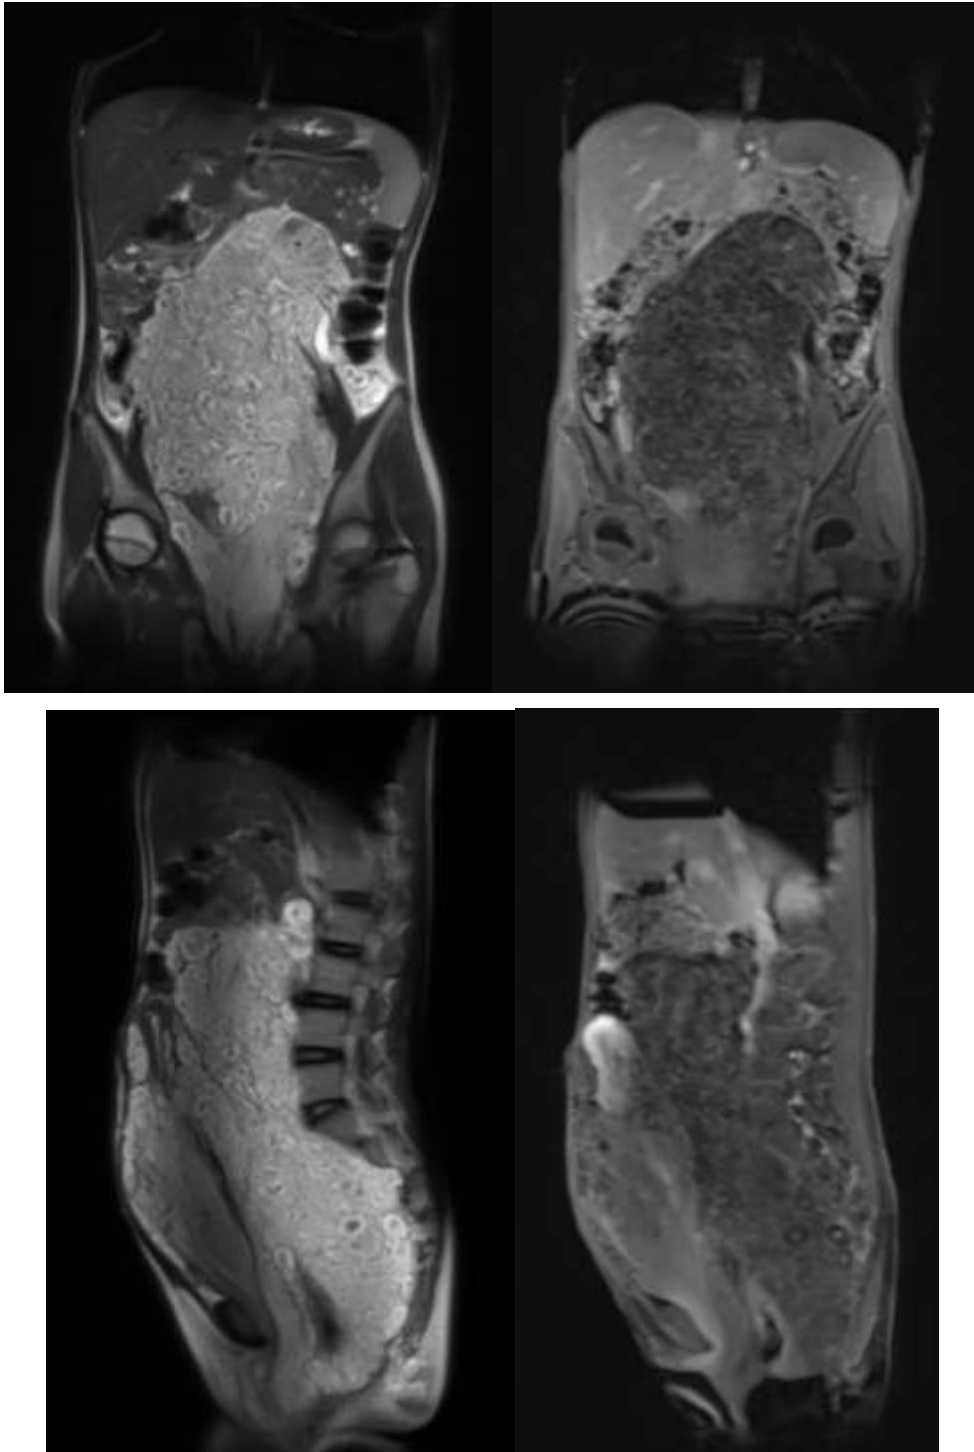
MRI examination of the coronal & sagittal fragment showed a broad hyperintense confluent multinodular mass with multiple images of "target sign appearance" with intensity of hipointens in the mid and hyperintense in the peripheral part in T2 Haste and central enhancement in T1 Dixon W with contrast
